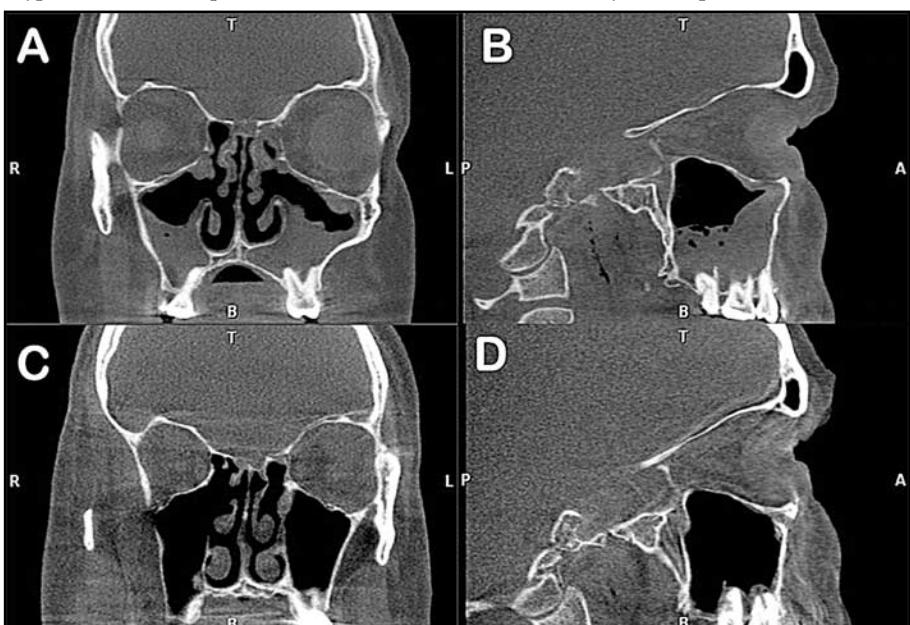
Computed tomography of persistent CR despite ESS and good ventilation (2a coronal and 2b sagittal). Near complete resolution post topical therapy (2c and d).
